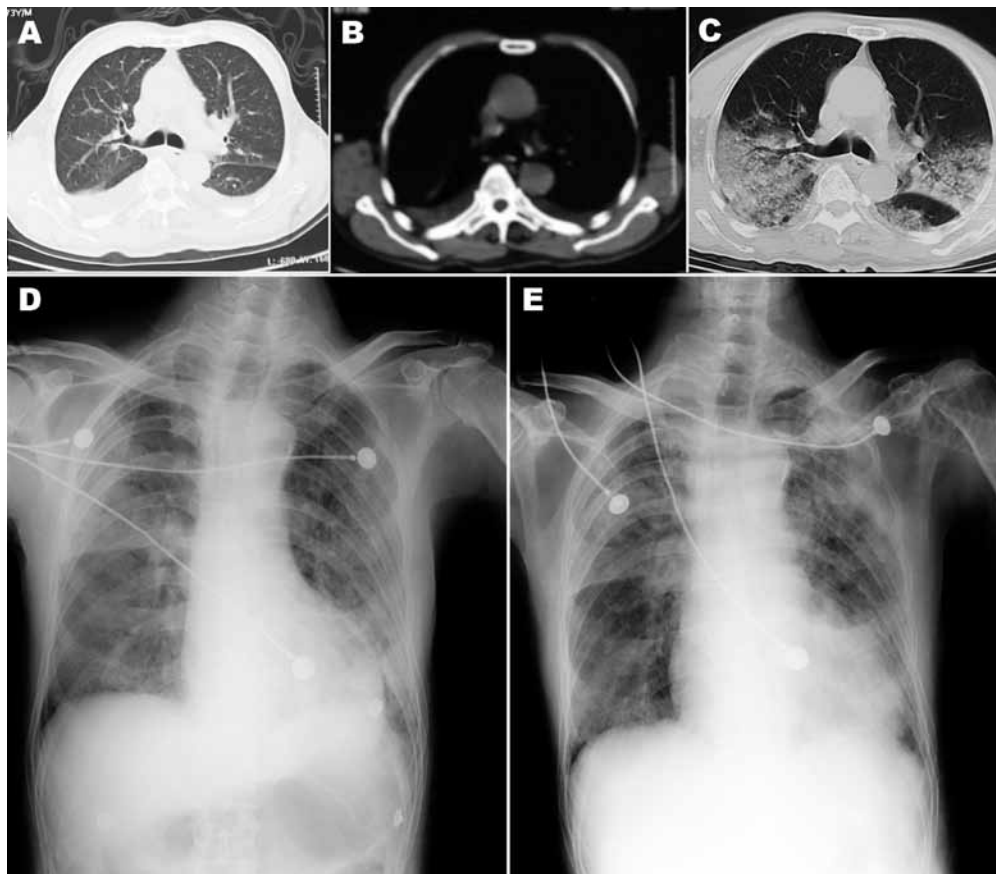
Chest computed tomography (CT) scan and radiograph images of patient (case-patient 1) in a study of 4 persons with early cases of influenza A(H7N9) virus infection, Shanghai, China. Images were taken 1, 5, 7, and 11 days after illness onset. A, B) CT scan images on day 1, showing bilateral pleural effusion but no obvious lesions. C) CT scan image on day 5, showing extensive ground-glass opacity and consolidation. D, E) x-ray images on days 7 and 11, respectively, showing reduced light transmittance on both sides of the lung.
